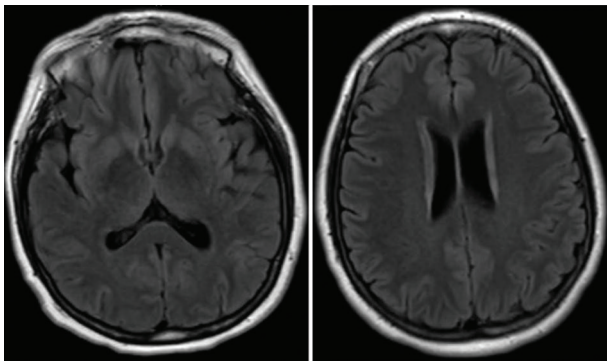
Magnetic resonance imaging findings. No abnormalities were observed in the evaluated anatomical structures. No signal abnormalities were observed in the diffusion. There is no evidence of chronic ischemic injury.
